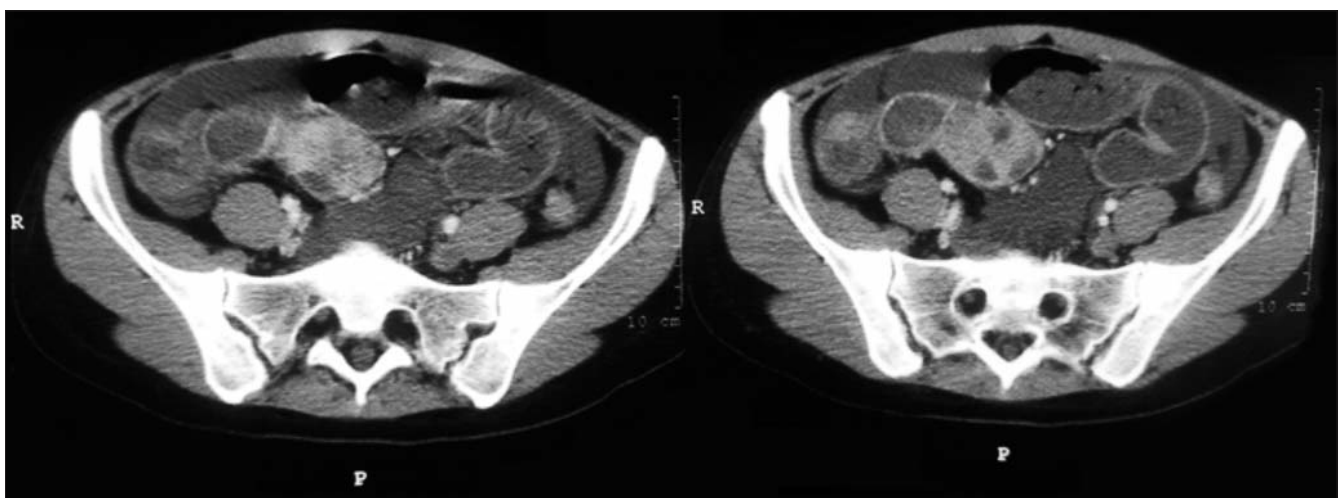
Preoperative abdominal CT scan – ileum tumor
